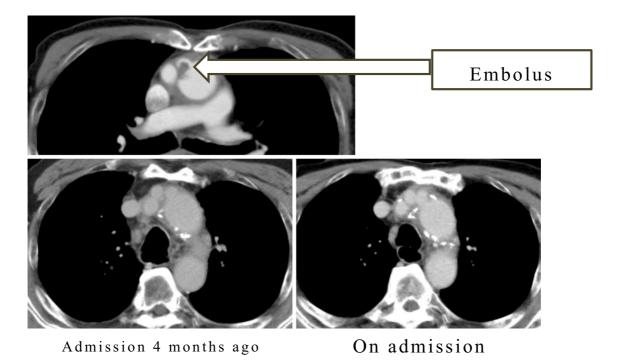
Chest CT scan image with contrast enhancement. Contrast-enhanced CT scan performed on admission showed embolus in proximal area of the left common carotid artery. First contrast-enhanced computed tomography (CT) scan performed on admission 4 months ago did not have increased soft tissue densities around the artificial graft and second contrast-enhanced CT scan performed on admission revealed ectopic increased soft tissue densities around the artificial graft suggesting a prosthetic graft infection.
